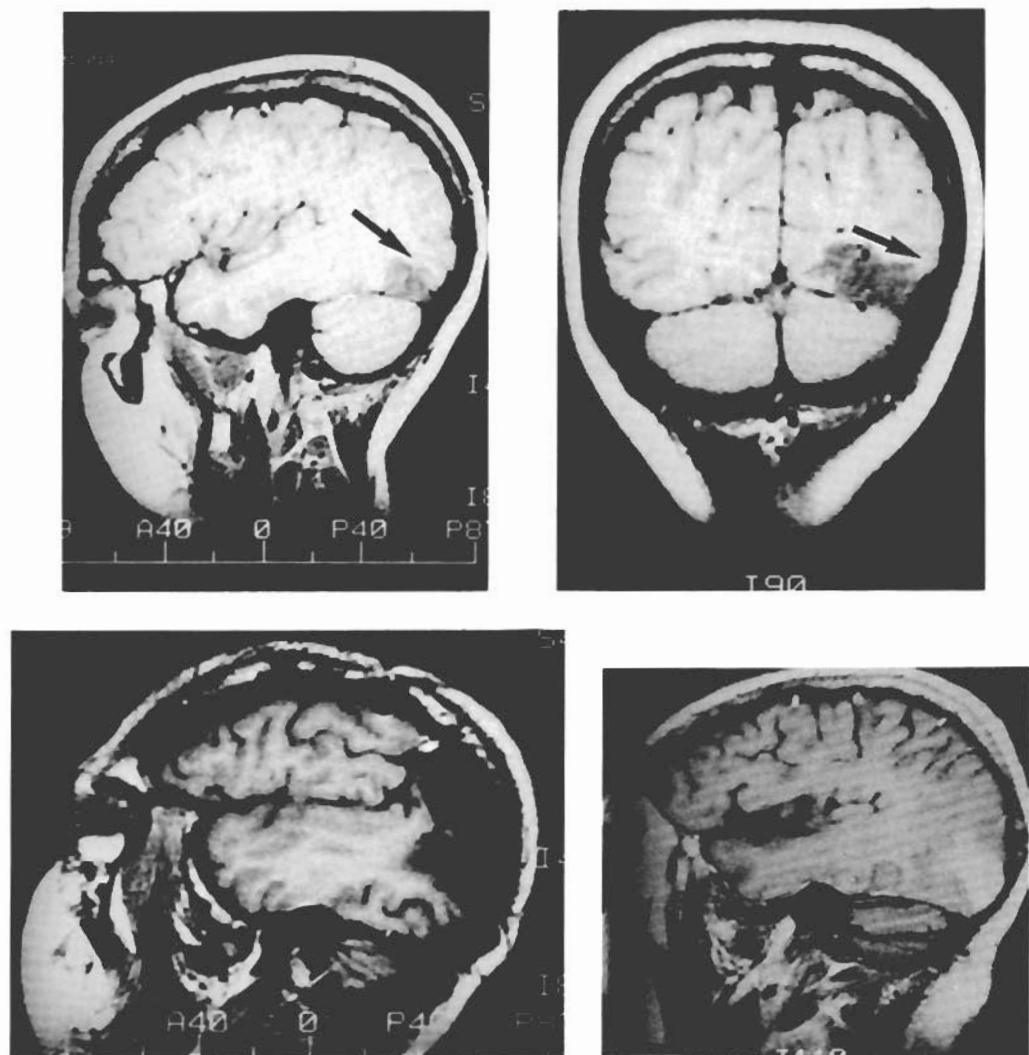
Magnetic resonance images of Cases 1, 2 and 3, all of whom demonstrated impaired motion perception in the contralateral visual field, are shown. The upper pair are lateral parasagittal and coronal images in Case 2. These are pre-operative images and the region of normal-appearing lateral occipital cortex damaged at surgery is indicated by the arrow (see also Figs 8 and 9). The lower two images are lateral parasagittal images from Case 1 (*left*) and Case 3 (*right*). Although the lesion in Case 1 is very extensive, the major overlap with the other two lesions is in its ventral extent, involving the lateral occipital gyri.
